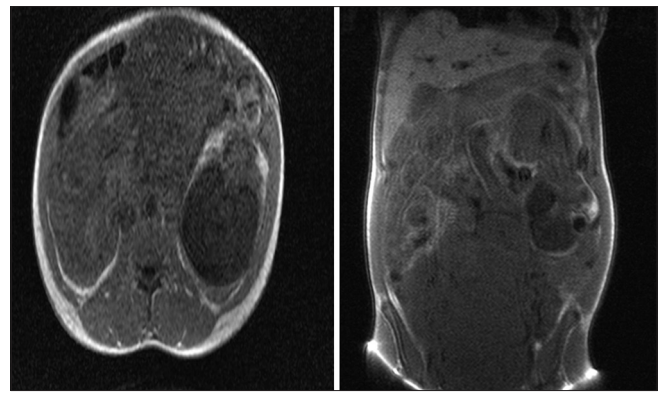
Preoperative magnetic resonance imaging showing the fetus lying freely in the peritoneal cavity. The placenta was located superior to the uterine fundus (second image)
